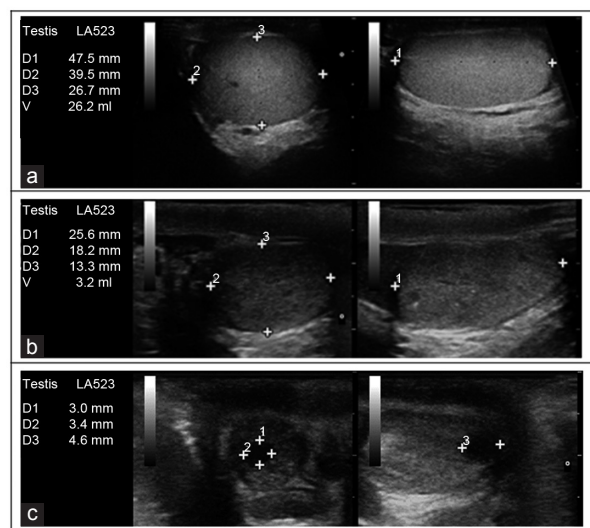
Testicular ultrasound parenchymal classification. (a) Testis with homogeneous isoechoic echo pattern (Type 1 homogeneity). (b) Testis with Type 2 inhomogeneous hypoechoic echo pattern and diffuse hyperechoic spots. (c) Testis with Type 3 inhomogeneity (lesion suspected for malignancy). Numbers (1, 2 and 3) represent the three diameters taken during US evaluation. US: ultrasound; D: diameter; V: volume.
